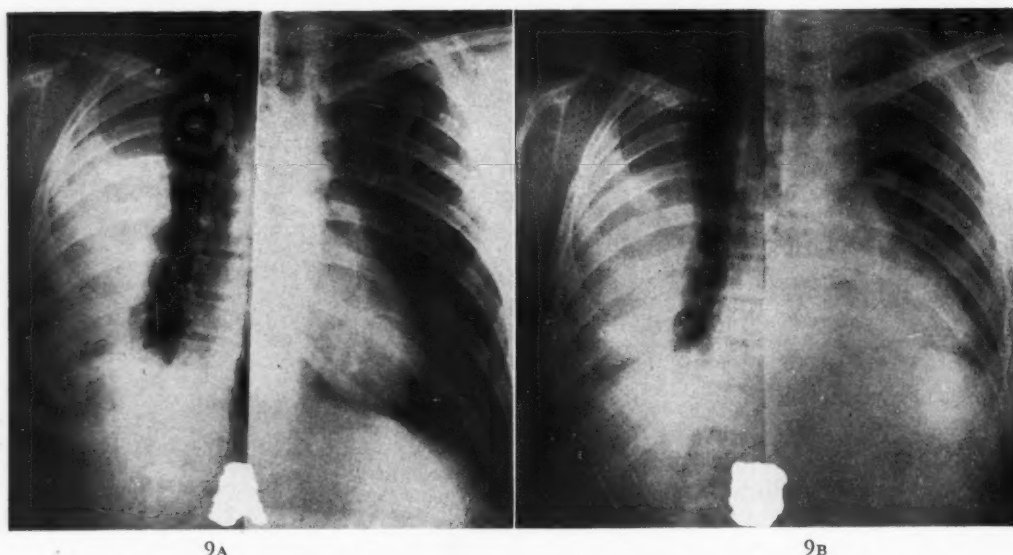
Case IX. Roentgenograms of chest; A, full inspiration; B, full expiration.
